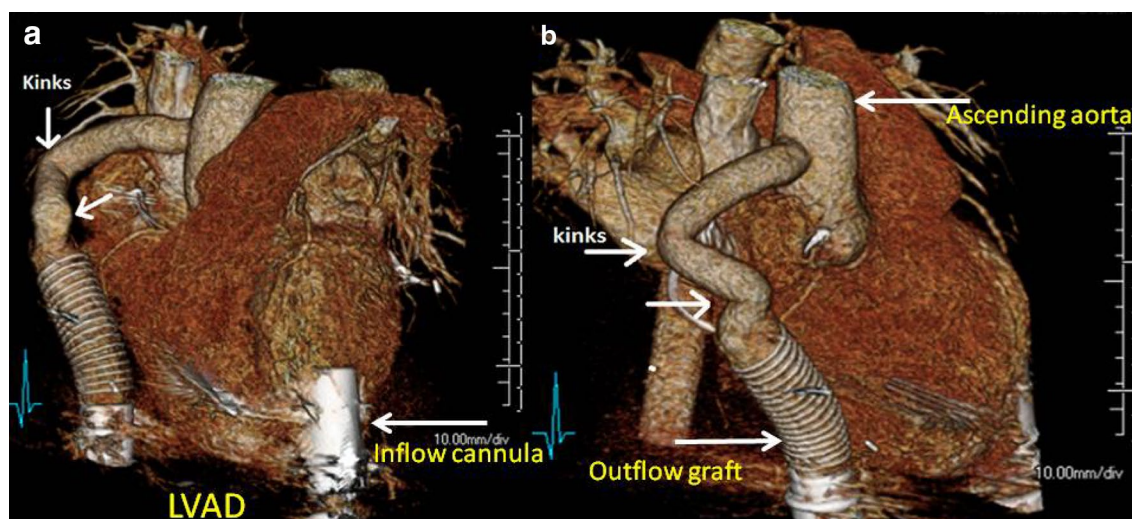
CT scan of the 42-year-old man with HeartMate II left ventricular assist device (LVAD) demonstrating the multiple kinking of the outflow graft (arrows) due probably to the adjusted outflow graft being too long in the primary implantation. LVADs have been increasingly used for patients with advanced heart failure (HF) with consequent increase in intensive care admission due to adverse events or as initial bridge from extracorporeal membrane oxygenation (ECMO)
